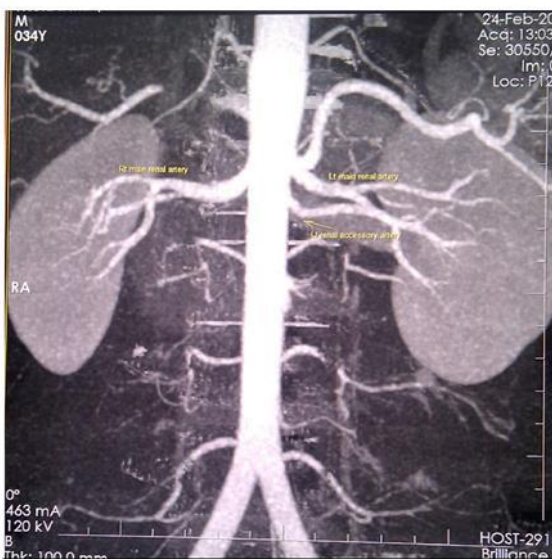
MIP CTA- Right: Length \times Height \times Width (9.83 \times 4.59 \times 4.38 cm) size, main right renal artery diameter is 4.8 mm. Left: Length \times Height \times Width (10.0 \times 4.48 \times 4.93 cm) size, main left renal artery diameter is 3.8 mm and accessory artery is 2.3 mm.
